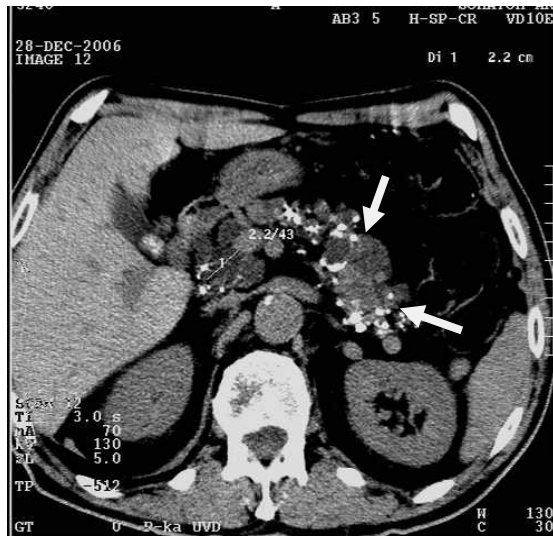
CT. The pancreas is deformed. Its structure non-uniform. Calcifications in pancreas (arrows are specified separate calcifications). A chronic pancreatitis
